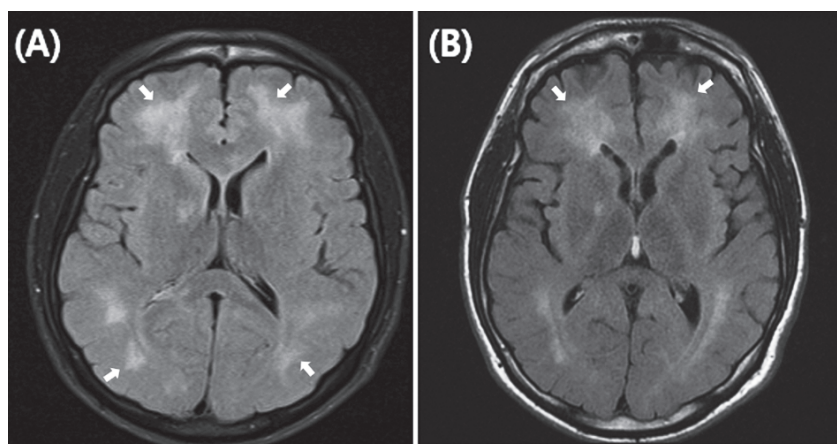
Brain MR images (A) before and (B) after repetitive hyperbaric oxygen therapy
